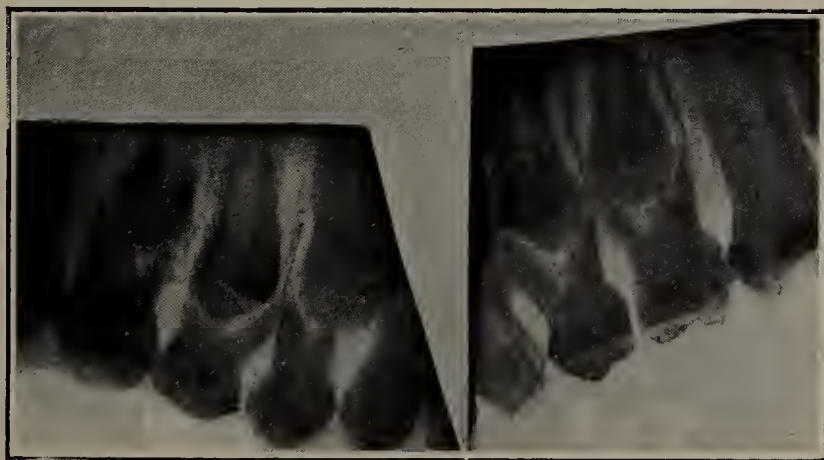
Patient of Dr. Clapp. (Age fifteen.) Left superior temporary central and cuspid still in place. Taken to ascertain if the permanent central was in the jaw. X-ray photograph shows it, and also that the apex of root is still unformed.
